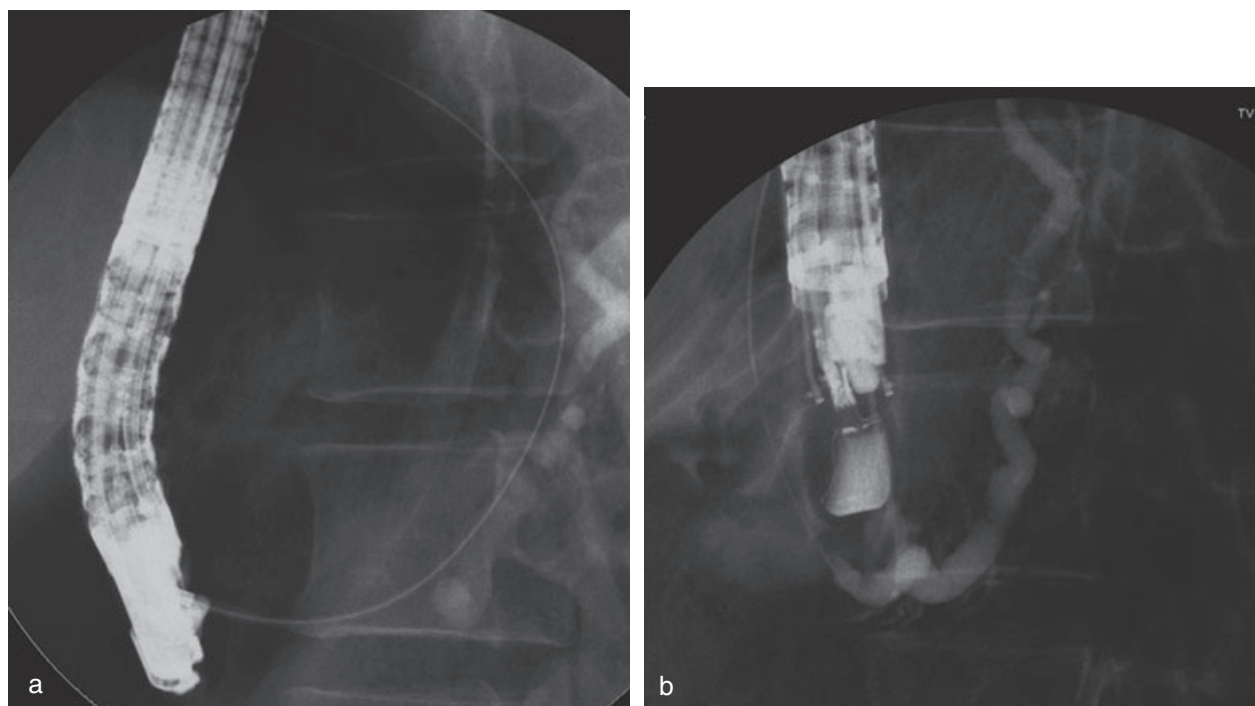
Endoscopic ultrasonography (EUS)-guided pancreatic access for rendezvous endoscopic retrograde cholangiopancreatography (ERCP) drainage in case of the stenosis of the orifice of pancreaticogastrostomy. (a) EUS-guided pancreatogram, showing the guide wire tracking distally through the orifice of the stoma into the stomach. (b) Fluoroscopy showing the retrieval of the guide wire into the working channel of the duodenoscope.
